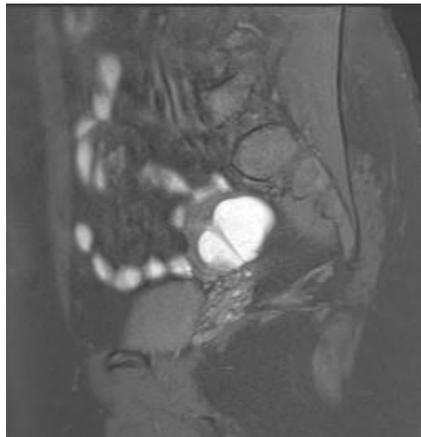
Sagittal T1-weighted fat-suppressed image shows the same findings.
